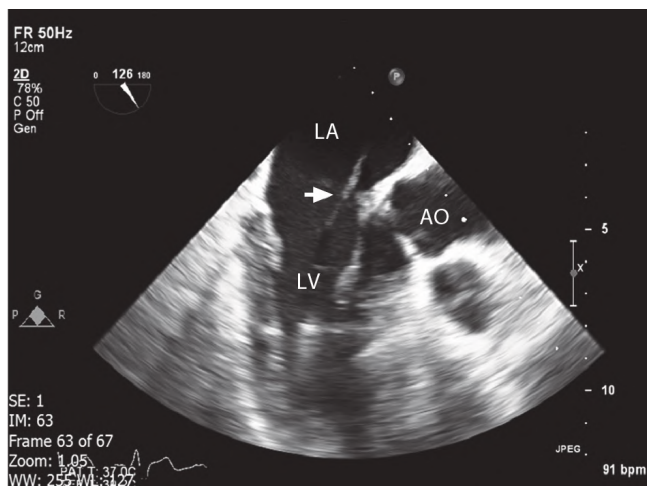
Two-dimensional transesophageal echocardiography in the long axis-view shows the pacing lead (arrow) in the left atrium. The lead passes across the mitral valve to the left ventricle.
